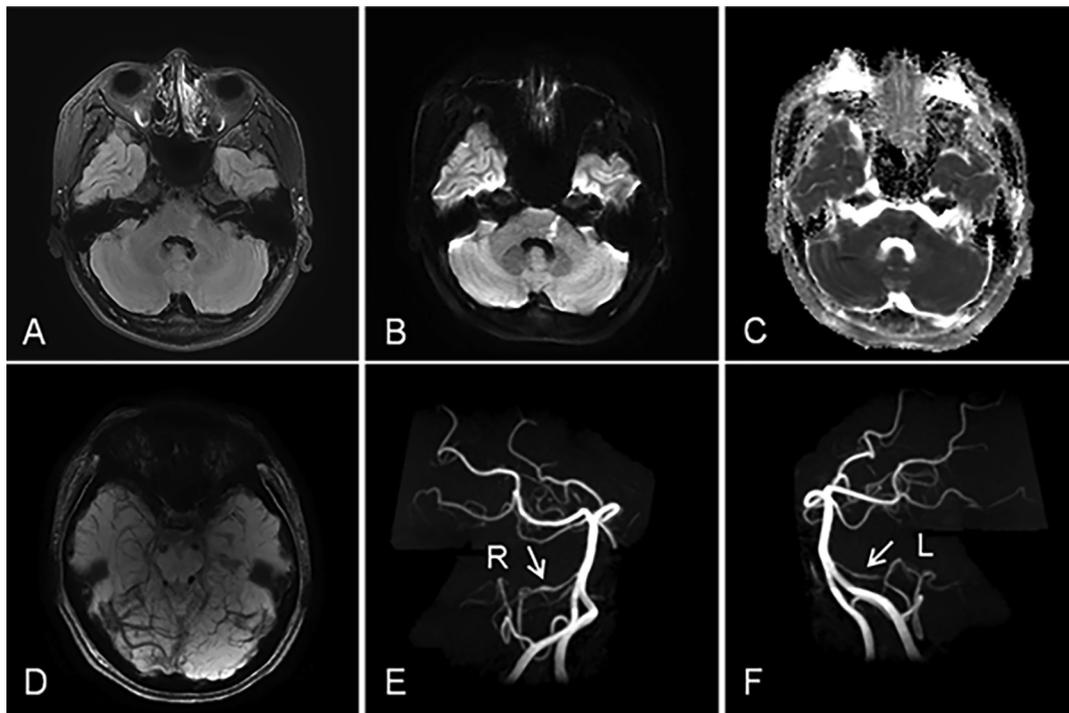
Brain MRI and MRA showing neurologic complications associated with EBV-T/NK-LPD. (A) Axial FLAIR image demonstrated high signal intensity in left lateral pons. Simultaneously, diffusion weighted image showed high signal intensity (B) with low apparent diffusion coefficient values (C) in the same lesion, which was suggestive of acute infarction. (D) Susceptibility weighted imaging revealed multiple foci of hypo-intense signal in the both surface of midbrain, representing multiple small hemorrhage. (E, F) MRA demonstrated irregularities on both anterior inferior cerebellar arteries (AICA). White arrows indicate right AICA (E) and left AICA (F), respectively.
